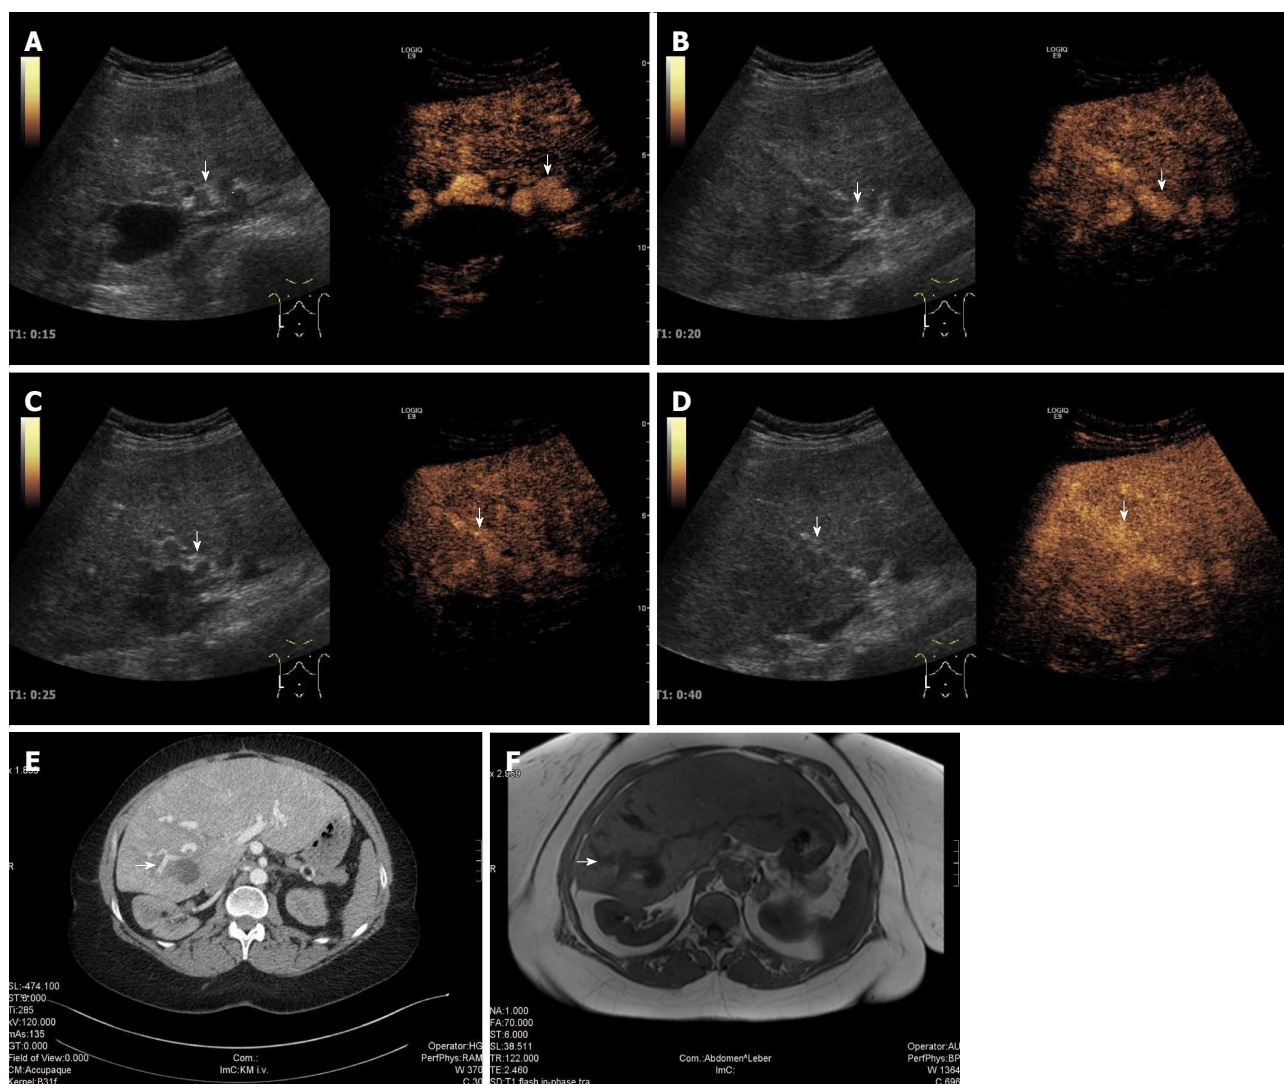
HVaM in a 46-year-old woman. B-mode and dynamic images detected in the arterial phase of contrast-enhanced ultrasound (CEUS) (A-D) compared to contrast enhanced magnetic resonance imaging tomography (MRI) (E) and computerized tomography (CT) (F) images. Intrahepatic arterial hypervascularization with tortuous hepatic artery in segment IV, VI, VII and VIII of the liver. Enhanced mean diameter of the hepatic artery (14.4 mm) intra- and extrahepatic. Intrahepatic non/hypoechoic (B-mode), hypodense (CT) and hypointense (MR; T1-phase) lesion without enhancement (CEUS) in segment V, VI of the liver corresponding most likely to bilioma.
